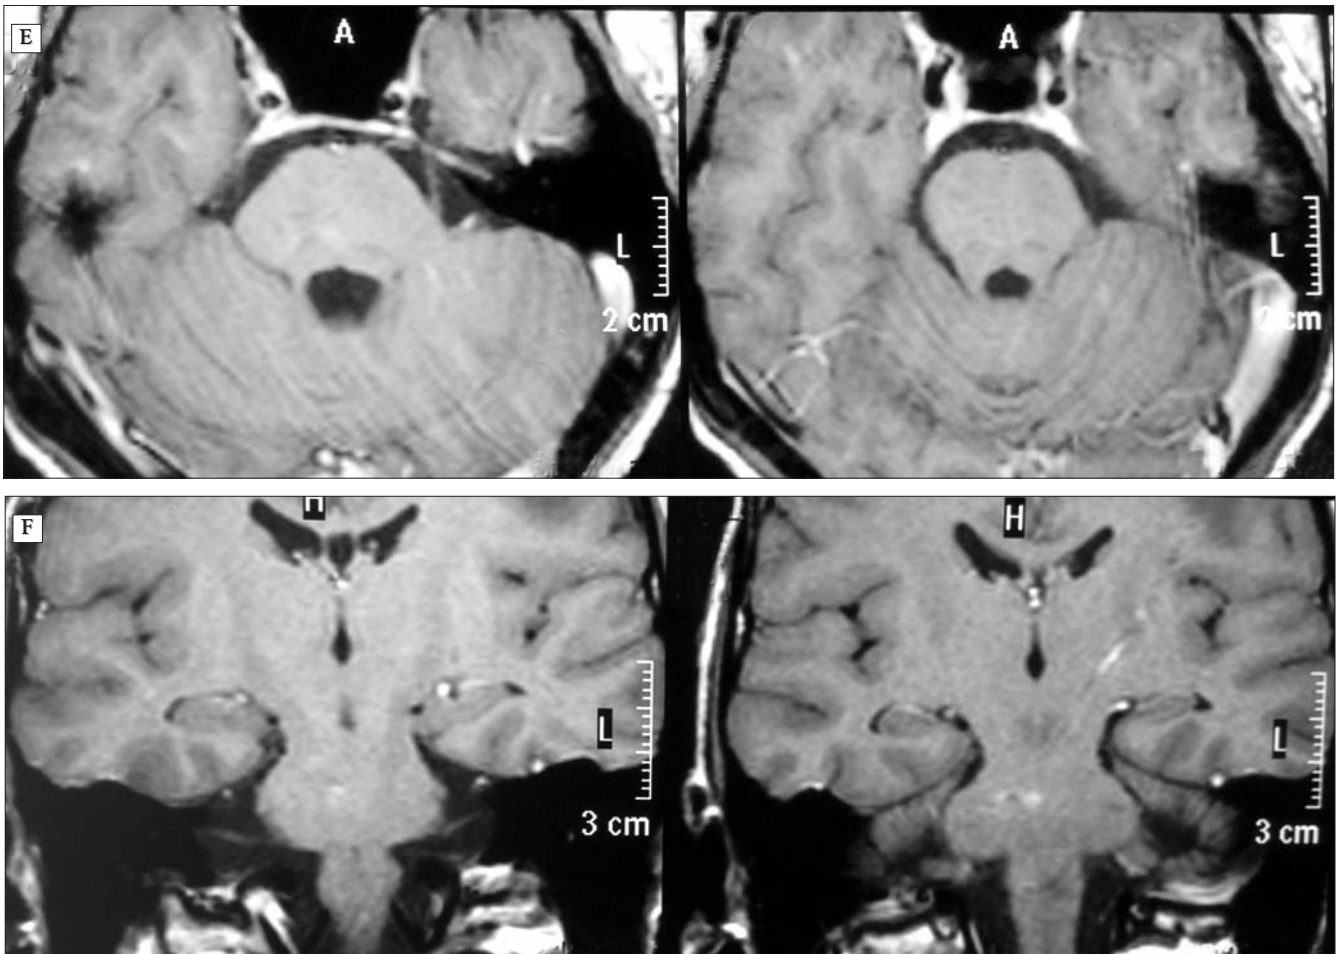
Male, 56 years old, known with a lung abscess, operated on by stereotactic aspiration for a deep-sited brain stem abscess. (E,F) 6 months postoperative axial and coronal gadolinium enhanced MRI images, showing the complete resolution of the brain stem abscess
